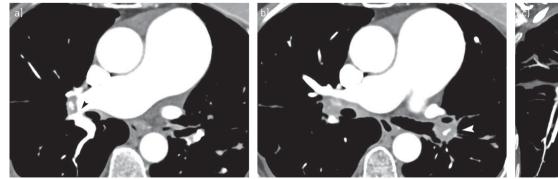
Images show chest CT angiography in a 25-year-old man with persistent dyspnoea 1 year after bilateral acute pulmonary embolism (PE), suggestive of interim development of chronic thromboembolic pulmonary hypertension. a-c] Transverse CT sections and d and e) maximum intensity projections in coronal oblique and f) transversal views show numerous vascular features of chronic PE including partial filling defects (single white arrows and single black arrows), endoluminal band and web (white arrowheads), and severely stenosed pulmonary arteries (black arrowheads). Presence of systemic collateral supply from enlarged bronchial arteries (double black arrows in (e) and inferior phrenic arteries (white double arrows in (f)). Reperfusion of left interlobar pulmonary artery beyond its obstruction (black arrowhead in (e)) by ipsilateral enlarged bronchial arteries.
